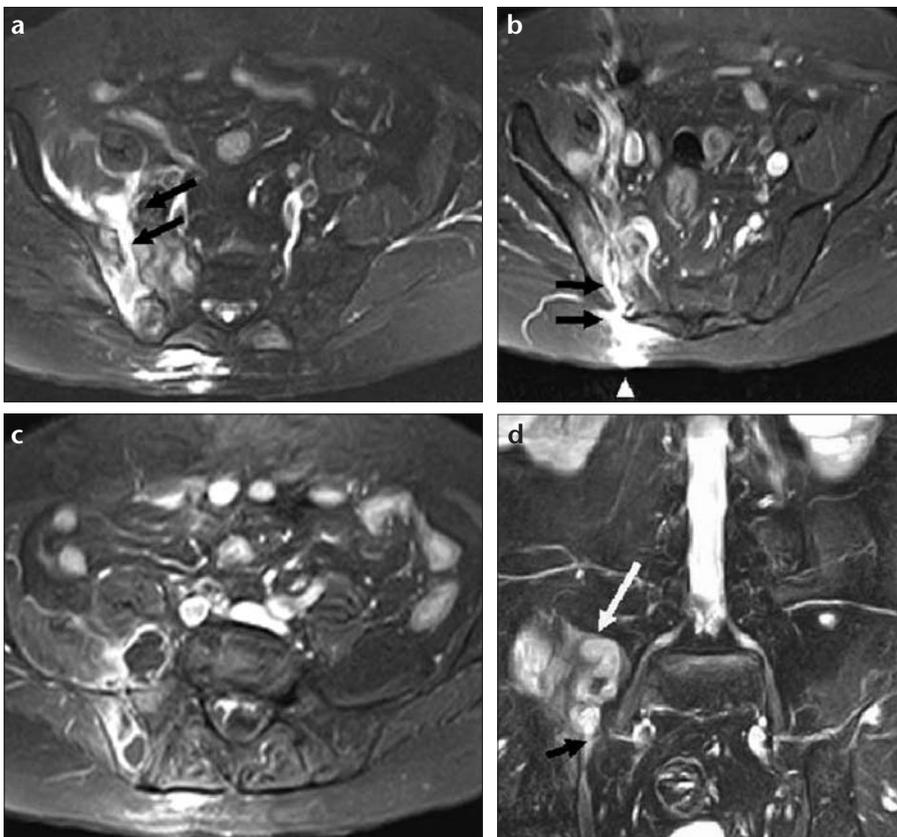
a-d. Tuberculous sacroiliitis in the same patient as in Figure 1. Transverse T2-weighted SPIR TSE MR images (a, b) show advanced sacroiliitis and osteomyelitis with accompanying iliopsoas and gluteal abscesses. High signal intensity pus drains into the iliopsoas region (arrows, a), and the gluteal region (arrows, b). The sacroiliac joint space is enlarged with significant destruction of the joint margins. A draining sinus is noted in the gluteal region (arrowhead, b). Transverse post-contrast T1-weighted SPIR MR image (c) shows contrast enhancement in the joint space, iliac and sacral bones, as well as iliopsoas and gluteal abscesses, which is consistent with extensive sacroiliac joint and periarticular inflammation. The size and extent of the iliopsoas abscess (white arrow, d) are better shown on a coronal T2-weighted SPIR TSE MR image (d). It is obvious that the iliopsoas abscess is related to the sacroiliac joint inflammation (black arrow, d).
